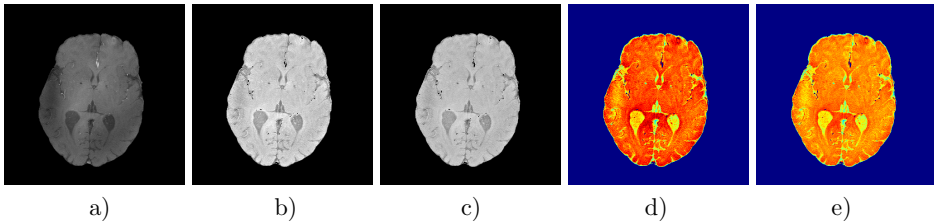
A restoration example from the 7T T1-weighted brain MR dataset: a) the original slice; b) the resulting image obtained applying the Guillemaud filter; c) restored image obtained applying HC-HUM; d) Figure 9 b) in false color; e) Figure 9 c) in false color. The red-shift (i.e. the halo color gamut) results to be more attenuated when using HC-HUM than in the Guillemaud case.
